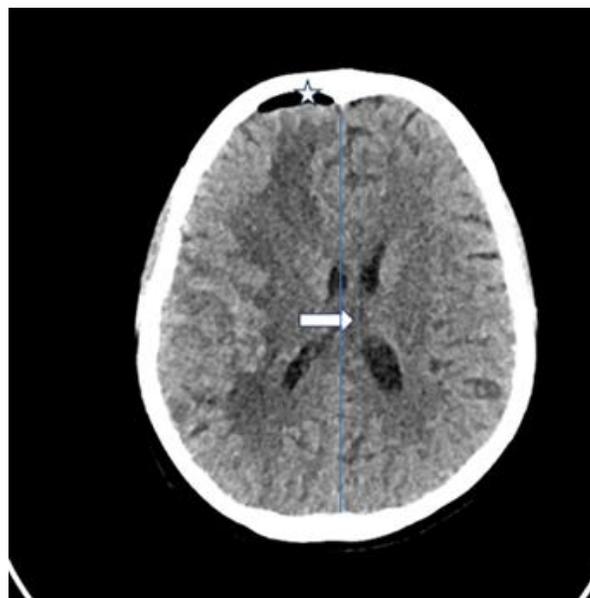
Axial unenhanced CT brain showing right frontal pneumocephalus (star) with midline shift to the left side (arrow).
